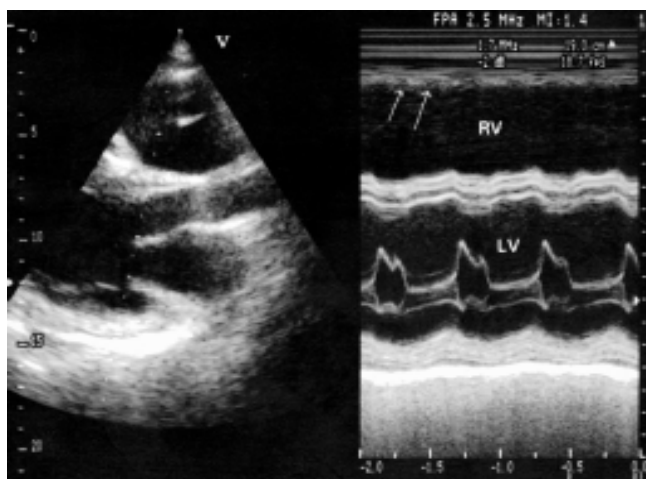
M-mode echocardiography shows thinning and marked reduced systolic thickening in the right ventricular wall (arrows). Note the dilatation and attenuated systolic functions of the right and left ventricles (LV, left ventricle; RV, right ventricle).
